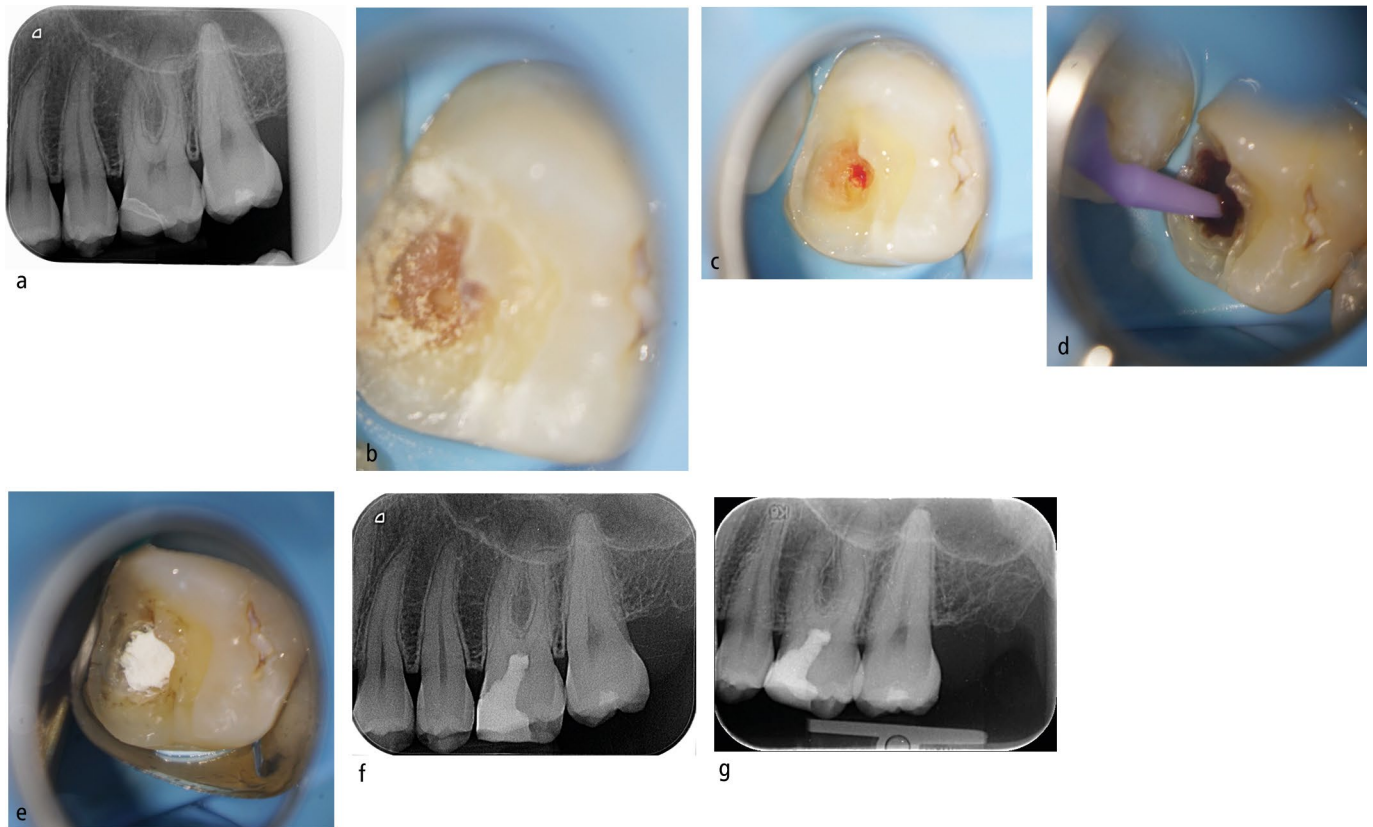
Full pulpotomy: clinical diagnosis of irreversible pulpitis 26. a) Periapical radiograph showing deep caries under onlay 26 with possible slight apical radiolucency palatal root. b) Presentation following gross caries removal with soft dentine remaining over pulp. c) Pulp exposure following hand excavation. d, e) Bleeding could not be controlled within five minutes using microbrush soaked in 2.5% hypochlorite so a full pulpotomy was completed until healthy vital pulp was reached. f) Six-month review periapical radiograph following full pulpotomy, showing the preservation of tooth tissue compared to conventional endodontics. g) Twelve-month review periapical radiograph showing no increase in apical radiolucency. Tooth has remained symptom-free (images courtesy of Luca Moranzoni and Jonathan Cowie)
